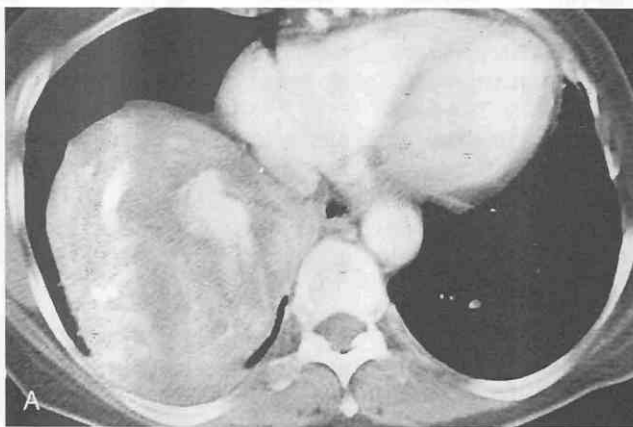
Hemangiopericytoma appearing as a large, hypervascular mass. A, Contrast-enhanced CT shows a large, right lower lobe mass. Large vessels can be seen within the mass. B and C, Axial T1-weighted (B) and fast spin-echo (C) MR images show a heterogeneous mass in the right hemithorax. Flow voids can be seen within the intratumoral vessels.
